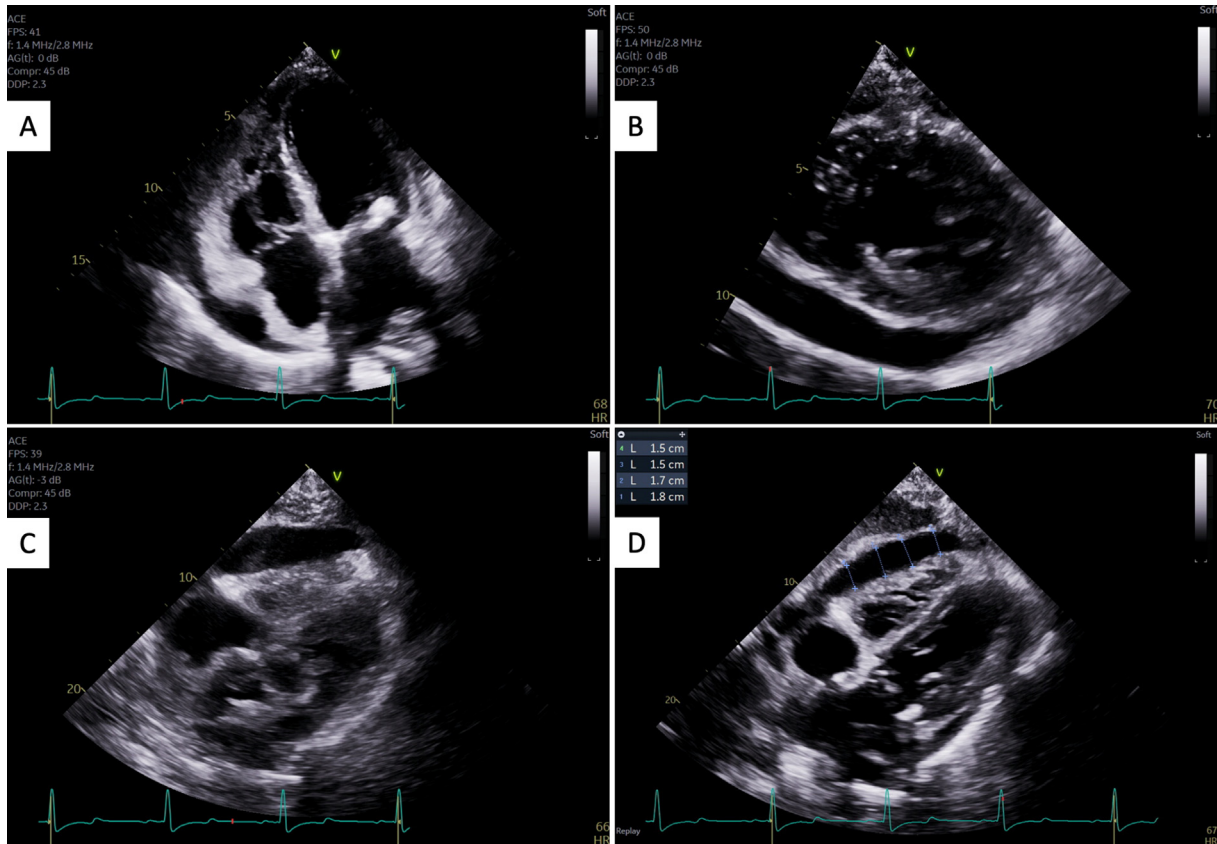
Transthoracic echocardiogram showing pericardial effusion with tamponade physiology. (A) 4-chamber view revealing large pericardial effusion with inversion of right atrial wall. (B) Parasternal short-axis view highlighting large pericardial effusion. (C,D) Subcostal view demonstrating large pericardial effusion with inversion of right ventricular wall.
